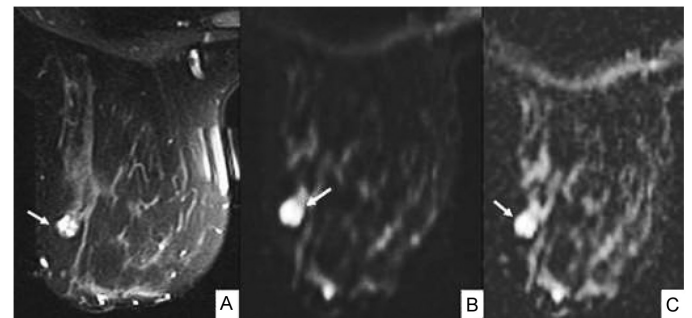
Contrast enhanced axial image (a), DWI (b), and ADC map (c) of a benign lesion (fibroadenoma).
